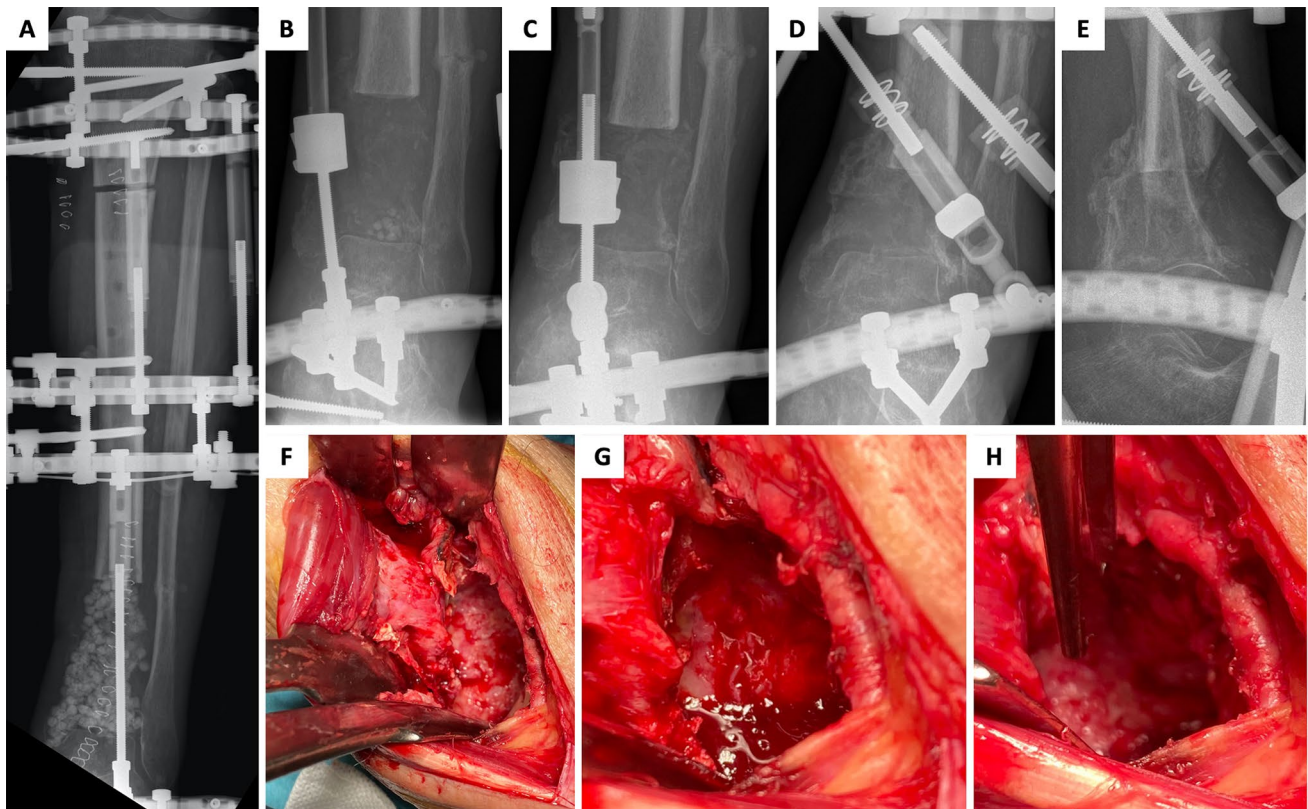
Distal tibia osteomyelitis in patient 1. A–C: AP radiographs of the left distal leg after debridement and bone transport surgery A and at 1 month B and 2 months C after the start of bone transport. D–E: AP and LL radiographs 5 months after the start of bone transport.
